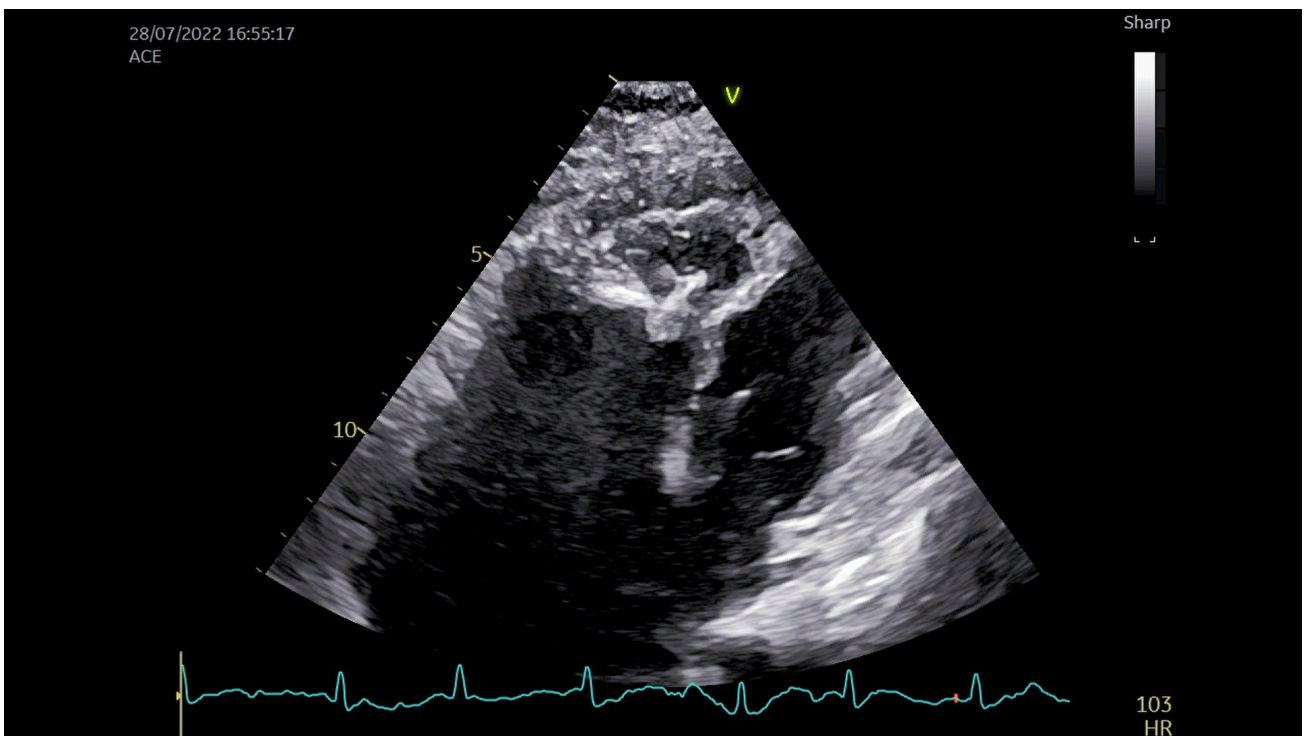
VO in EMF patient and APHCM patient. (A,B) EMF patient. In apical 4-chamber view, there was severe endocardial calcification (arrow), chambers were not clearly displayed, and chambers were clearly displayed on VO as “mushroom sign”. (C) APHCM patient. Ventricle opacification during diastole showed “spade-shape”. VO, ventricle opacification; APHCM, apical hypertrophic cardiomyopathy.
